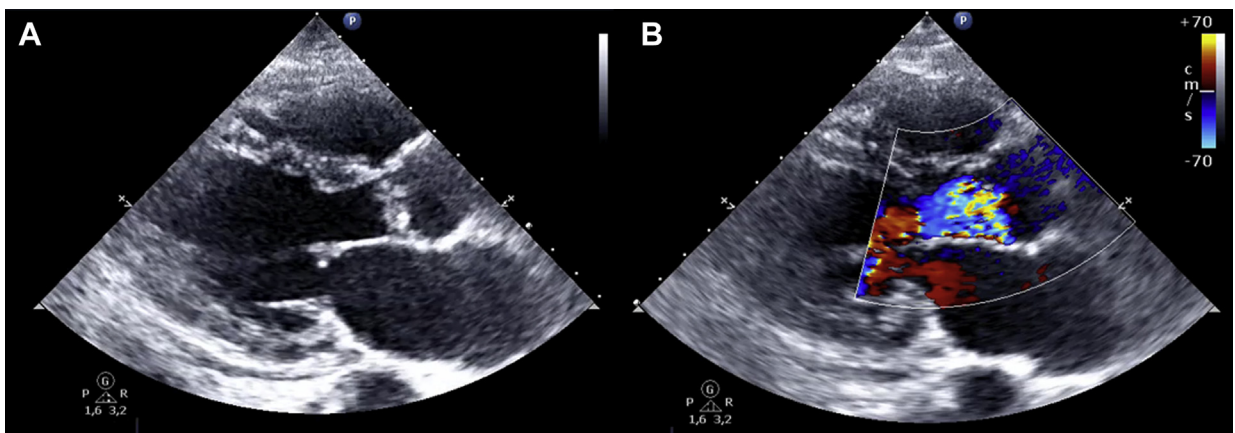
Long-axis parasternal view with transthoracic echocardiography revealed (A) thickening of the aortic cusps and (B) severe aortic regurgitation with color Doppler imaging.
